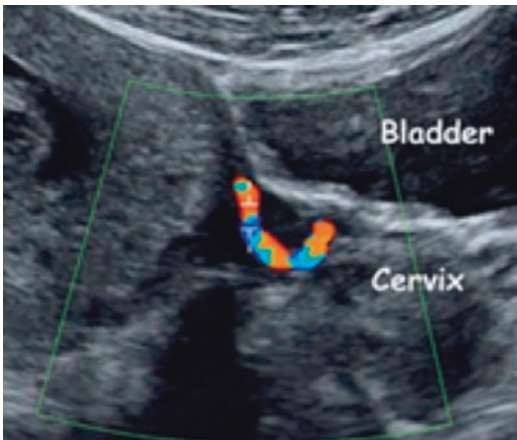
The ascending branch of the uterine artery at its paracervical section and at the point closest to the internal os. Pulsed wave Doppler has been used to obtain the flow velocity waveforms [20]
